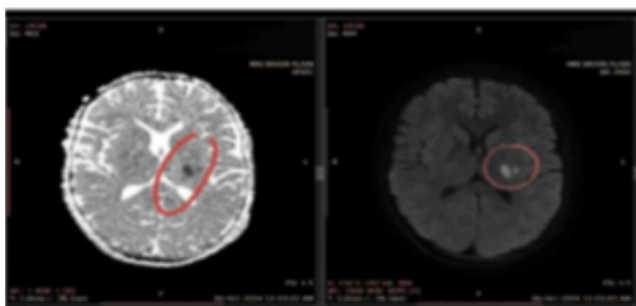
MRI brain shows areas of infarct in red markings. ADC image on right and DWI image of brain on left
